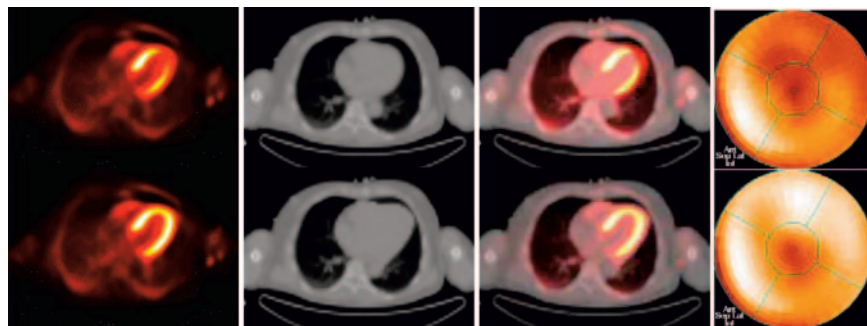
Application of emission-driven AC. Initial data showed significant mismatch between PET and CT data used for AC in patient without regional perfusion defects. Apparent reduced tracer uptake in anterolateral segments is clearly visible in fused image display and in polar map (top). On basis of assumption that tracer uptake (even if reduced) can be emitted only from cardiac tissue, attenuation map was modified and image reconstruction repeated, resulting in substantial recovery of tracer uptake. Ant = anterior; Inf = inferior; Lat = lateral; Sep = septal.
